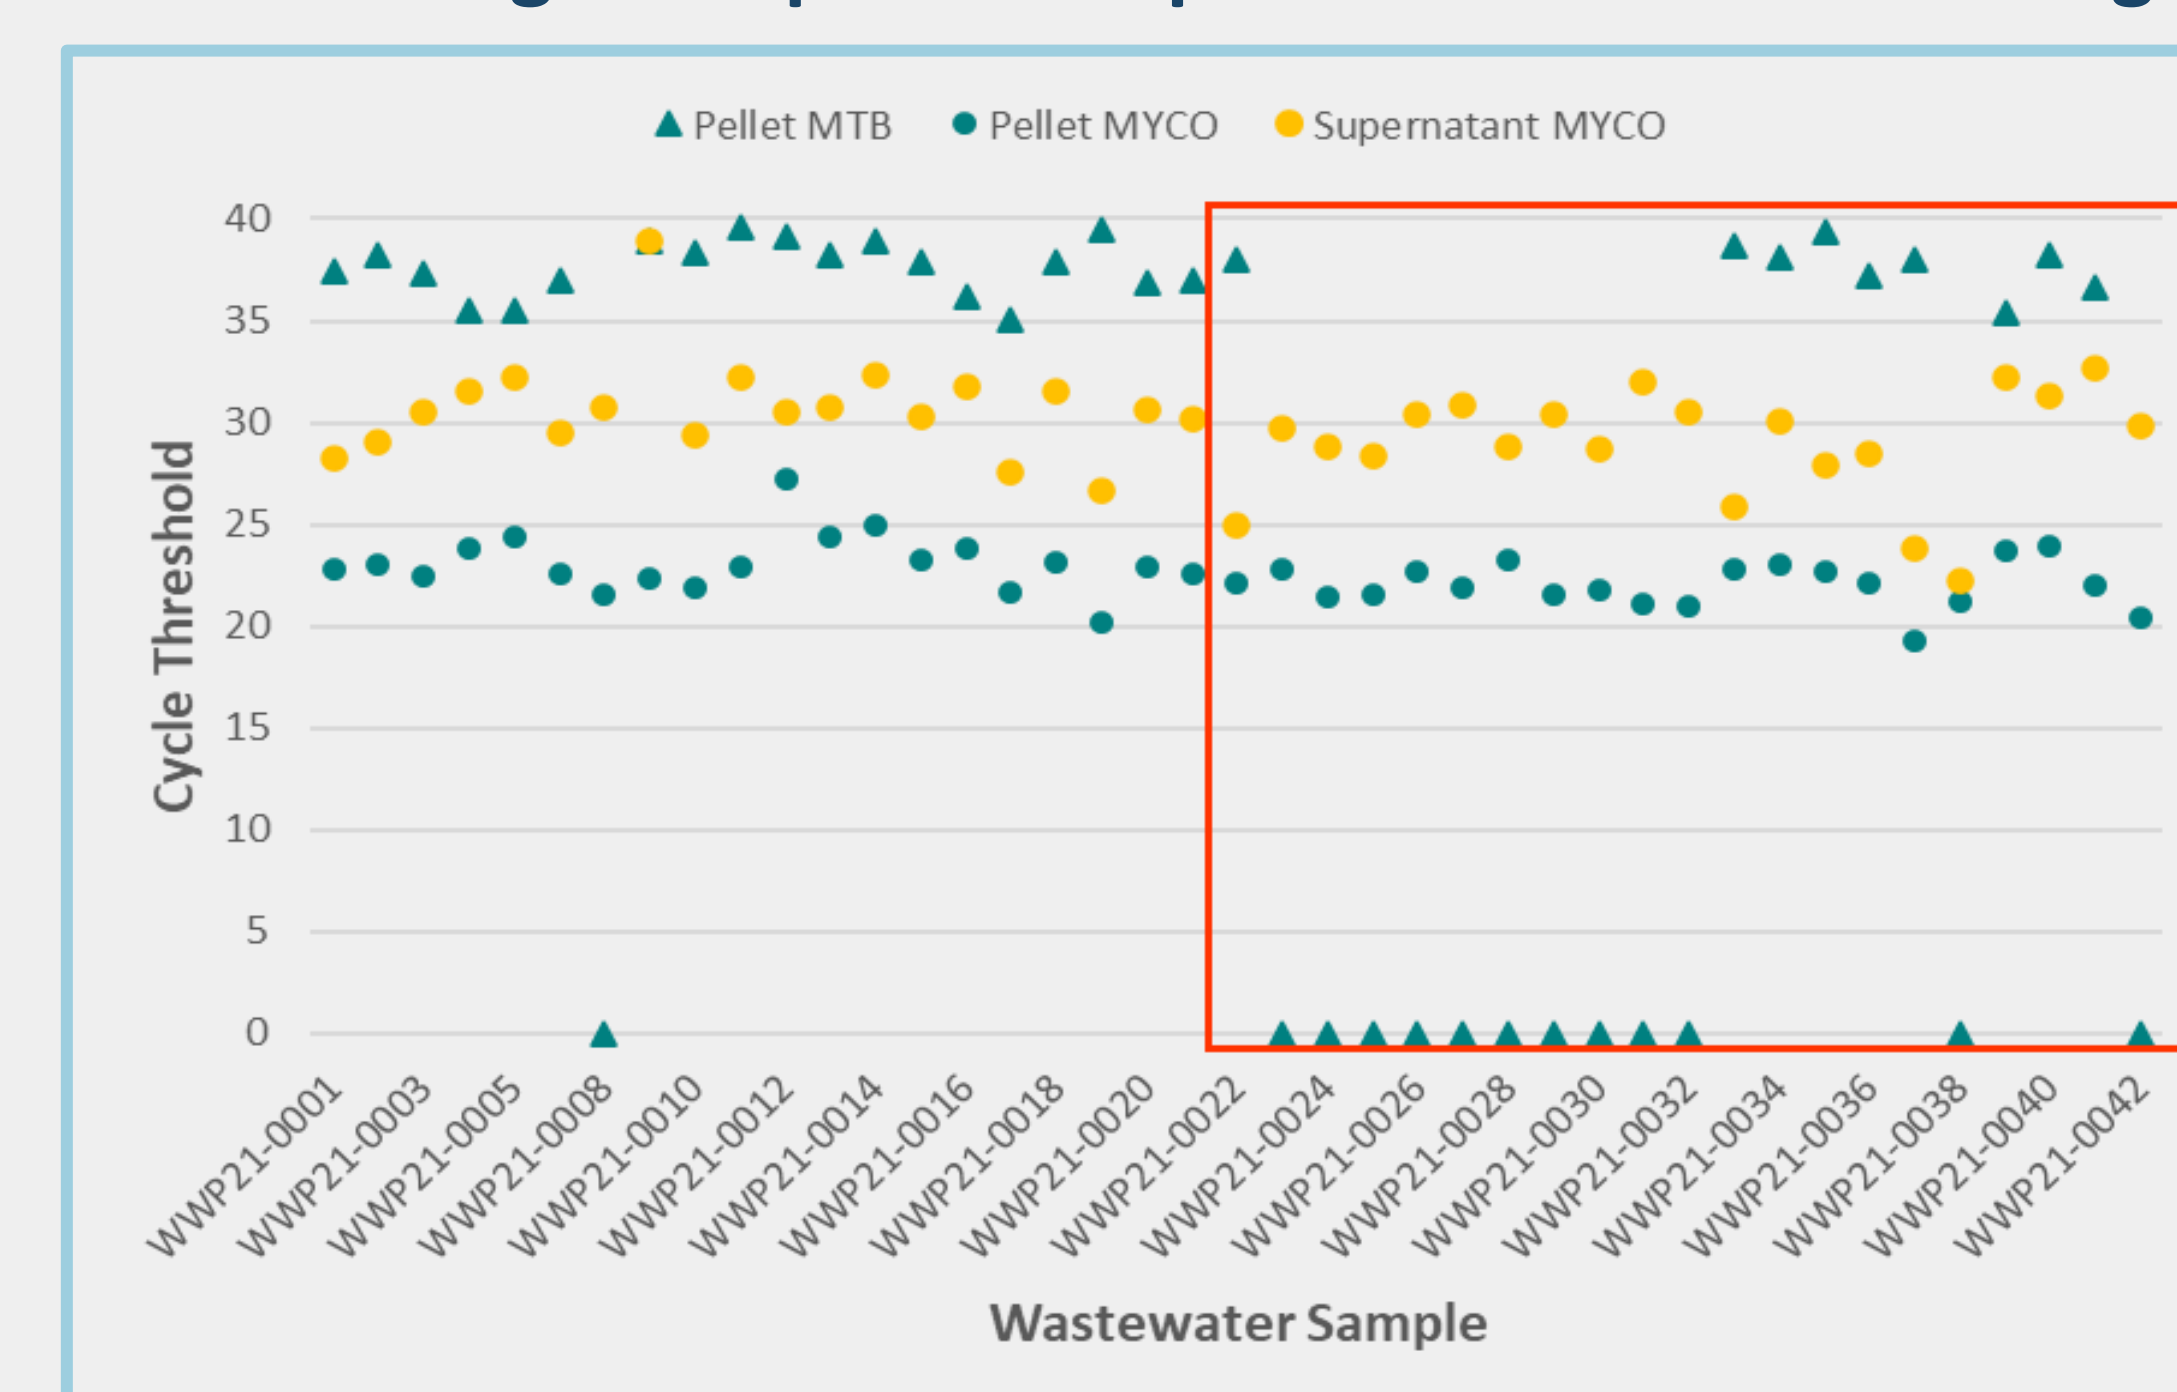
Real-time PCR Detection of MYCO and MTB in WW pellets and supernatants. Cycle threshold (CT) indicates how many DNA replication cycles occurred when a positive result was detected, higher concentrations of target DNA will have lower CTs. MYCO (circle) were detected in all samples. Low-level amplification of MTB (triangle) DNA occurred in 68% of pellets, however MTBC was not detected in any of the samples. Therefore, MTB CTs were considered false positives resulting from non-specific amplification of the MTB target, which it did with great success (red outline).
